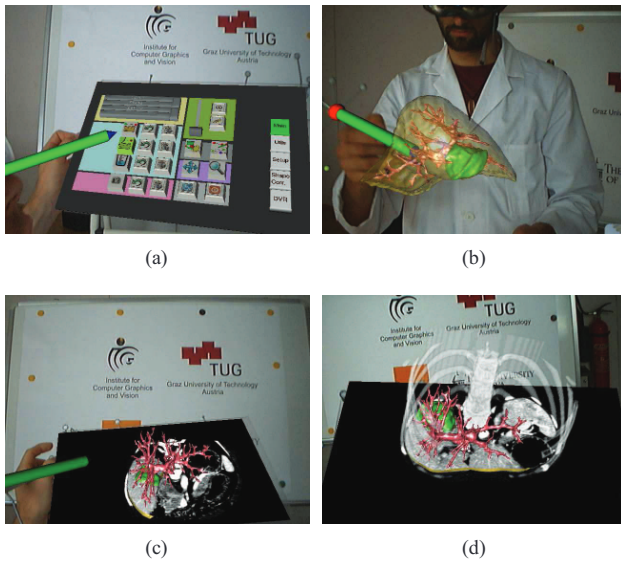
Exploration of liver data sets within the augmented reality environment. (a) 3D controls on the *PIP* allow for application control and setting of rendering parameters. (b) Observation of the organ from different viewpoints and distances by walking around or directly moving the object. (c) The back-side of the *PIP* shows original CT data. (d) Direct volume rendering provides true 3D context information.
